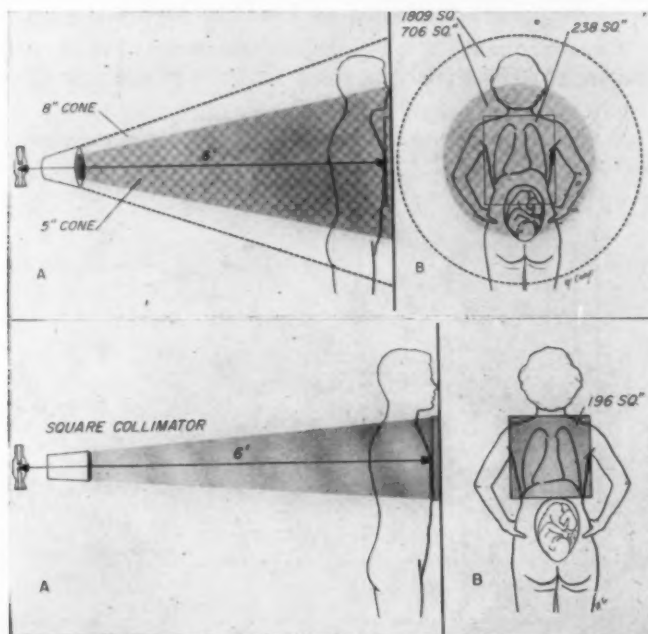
At "A" is shown a typical chest radiographic examination using either an 8" or 5" cone to cover a 15" x 18" cassette. Unnecessary exposure of the upper abdomen as well as other parts of the body are seen in "B".
